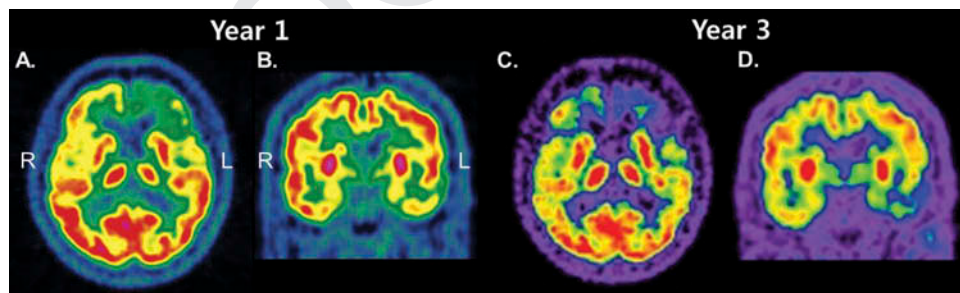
Brain FDG-PET scans of patient J. K. at Year 1 (A and B) and Year 3 (C and D): Axial (A) and coronal (B) scans at Year 1, and axial (C) and coronal (D) scans at Year 3. At the age of 59 (Year 1), FDG-PET scans reveal significant hypometabolism in the bilateral dorsolateral and medial frontal area, and anterior temporal lobe, both of which are more severe on the left than on the right side (A and B). At the age of 61 (Year 3), FDG-PET scans display aggravated hypometabolism patterns in comparison with scans acquired at Year 1 (C and D). [To view this figure in color, please see the online version of this journal.]
